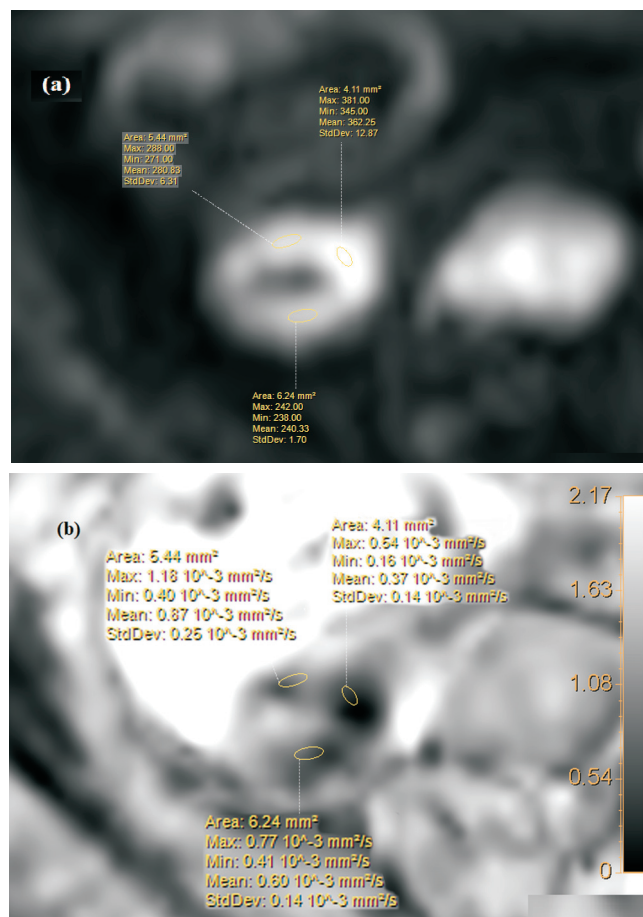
Selecting the ROI in SPIR-based DWI images ($b = 800 \text{ s/mm}^2$) of 56 y.o. female (a). On the corresponding ADC map (b), the chosen ROI appears automatically.
